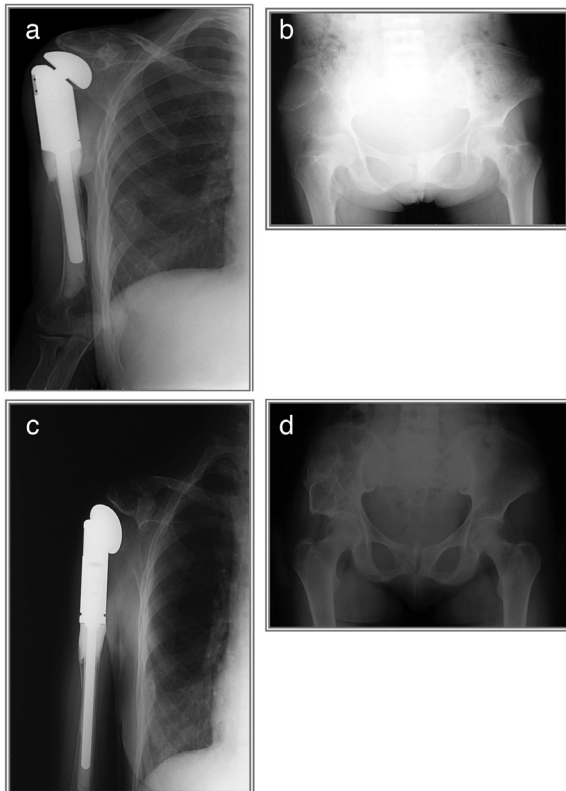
A 19-year-old female patient who underwent eccentric tumor resection due to right humeral lesion (patient numbered five) -; the significant change of the cyst in the iliac crest is particularly seen very well on the direct radiograph
